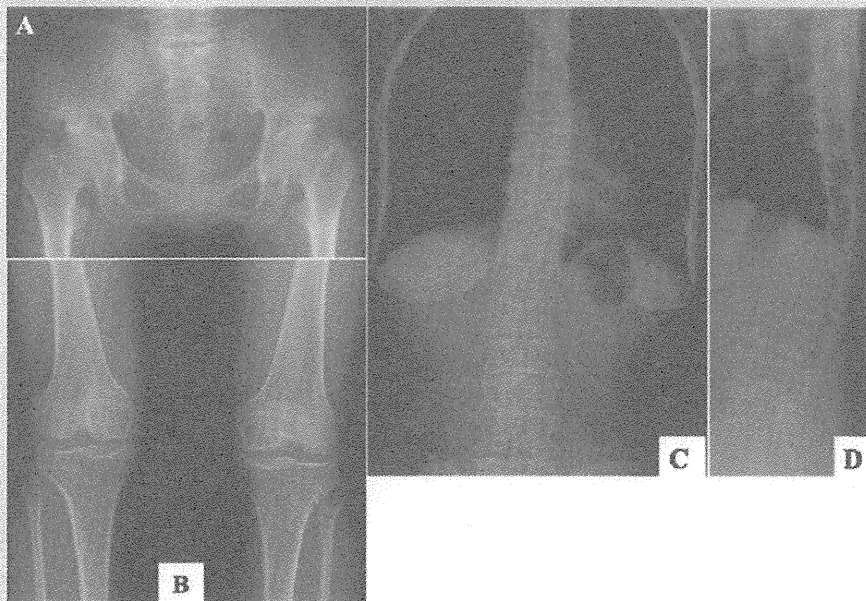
Radiographs of the mother of Patient 1 at age 33 years. A: Pelvis shows marked flaring of the ilia drooped down to the acetabulum with supra-acetabular notches. The femoral necks are short. B: Knee shows mild flaring of the distal femur and proximal tibial metaphyses. At the medial compartment, the distal femur is flat and the tibial plateau is depressed. C,D: Anteroposterior and lateral projections of the spine show thoracolumbar kyphosis, overfaced pedicles, platyspondyly with elongated vertebral bodies. Degenerative spondylosis ensues uniform narrowing of the intervertebral disc spaces.
